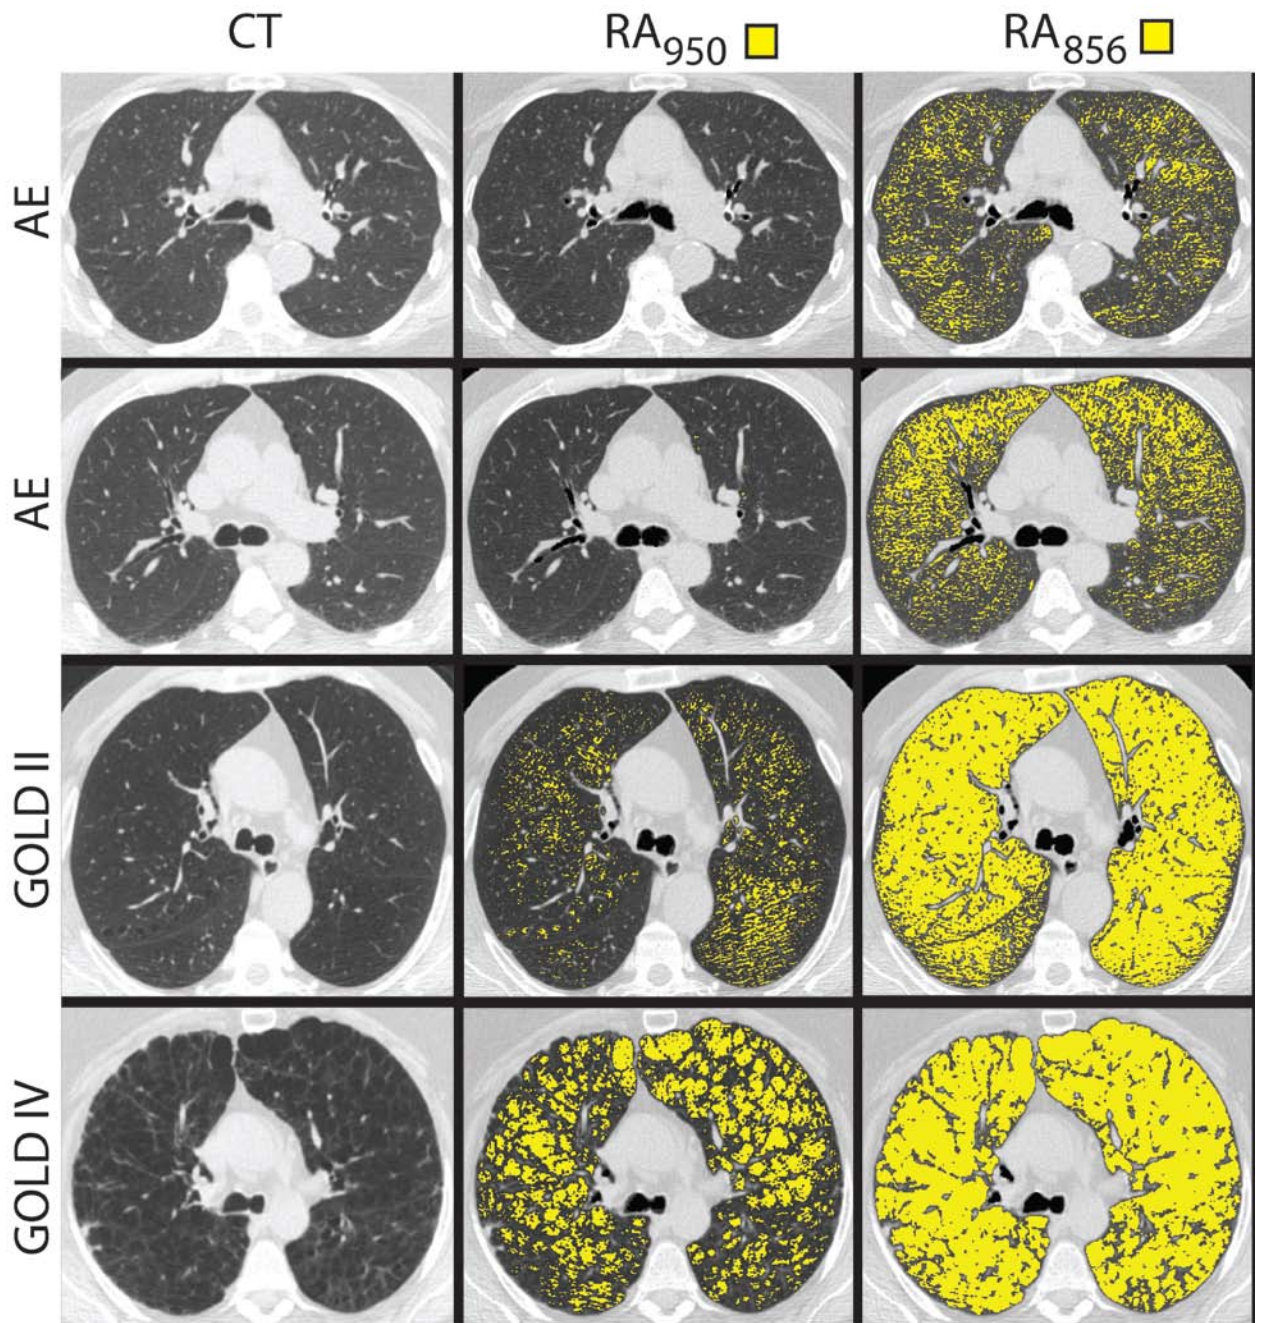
Axial center slice CT images for Representative AE and GOLD stage II and IV COPD subjects.
